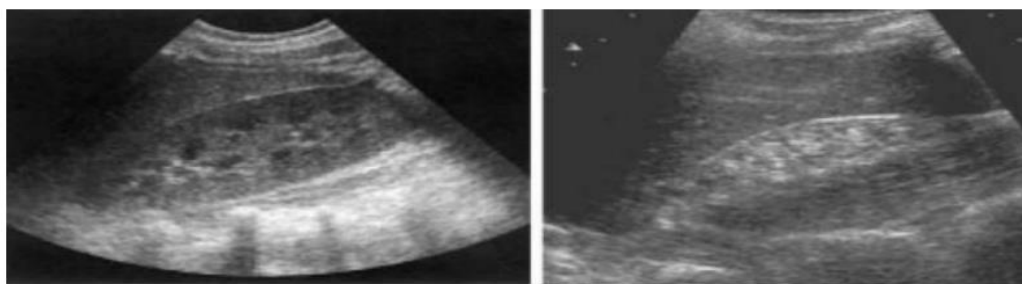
Ultrasonographic measurement of the length, depth and width of the kidney.
